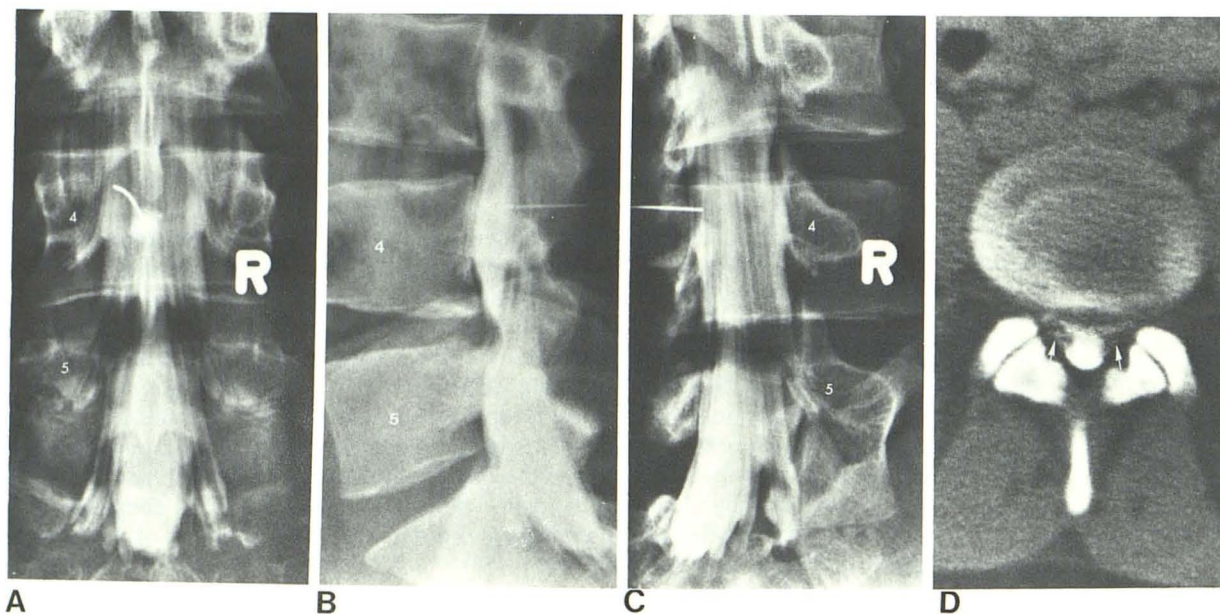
Diffusely bulging disk. A, Anteroposterior view from Amipaque myelogram. Symmetrical, rounded indentations of both lateral margins of thecal sac at level of L4–5 disk space. Despite these prominent indentations, L5 root sheaths are opacified. B, Horizontal beam prone lateral view. Bulging disk indents anterior margin of sac at L4–5, but contrast filling of L5 root sheaths partially obscures indentation. C, Right posterior oblique view. Defect is less impressive and located medial to right anterolateral sac margin. D, Axial CT image at level of lower margin of L4–5 intervertebral disk. Shallow concavity of anterior margin of contrast-filled thecal sac; indentation is most prominent centrally and nerve roots are displaced laterally to both sides (*arrows*). Crowding of nerve roots on each side prevents good opacification of anterolateral sac margins and accounts for bilateral filling defects in A.
